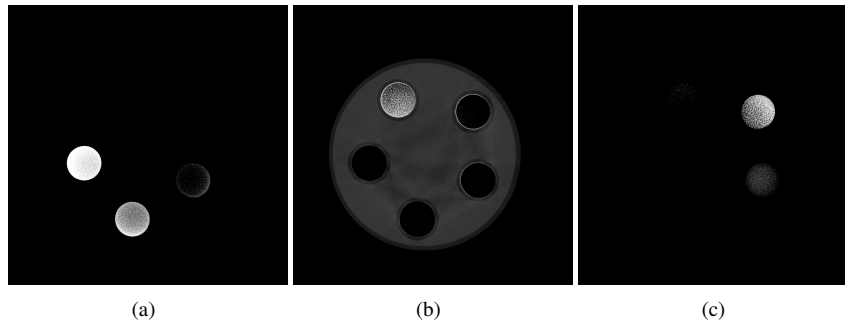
Decomposition in three basis materials of CT slices 4.13(a) and 4.15(b) showing the calculated volume fractions of the KBr solution (a), the $\text{Ba}(\text{ClO}_3)_2$ solution (b) and the PTA solution (c). A threshold of 0.5 was applied for each image.
